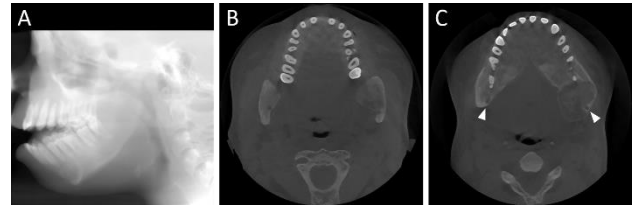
Antero-posterior view (A) of the scanned area in cone beam computed tomography showing the patient's profile and lack of vertical growth of the jaws. Axial sections confirm the expansion of the hard palate and left mandibular ramus (B) and presence of a heterogenous lesion in left mandibular ramus (C) displacing left mandibular canal comparing to the right side (arrow heads).
